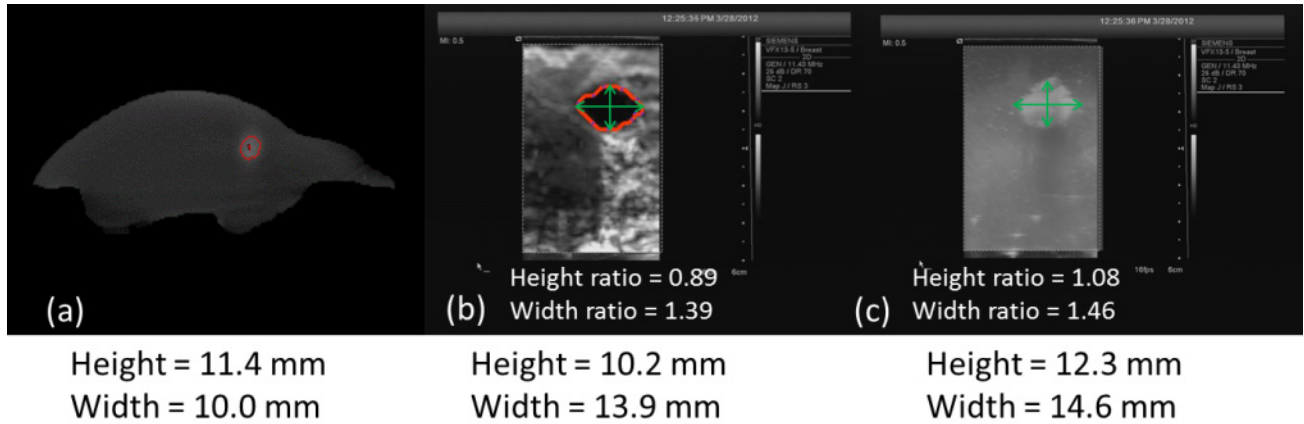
An example of the CT tumor dimensions (a), the corresponding strain tumor dimensions (b), and the B-mode tumor dimensions (c).
